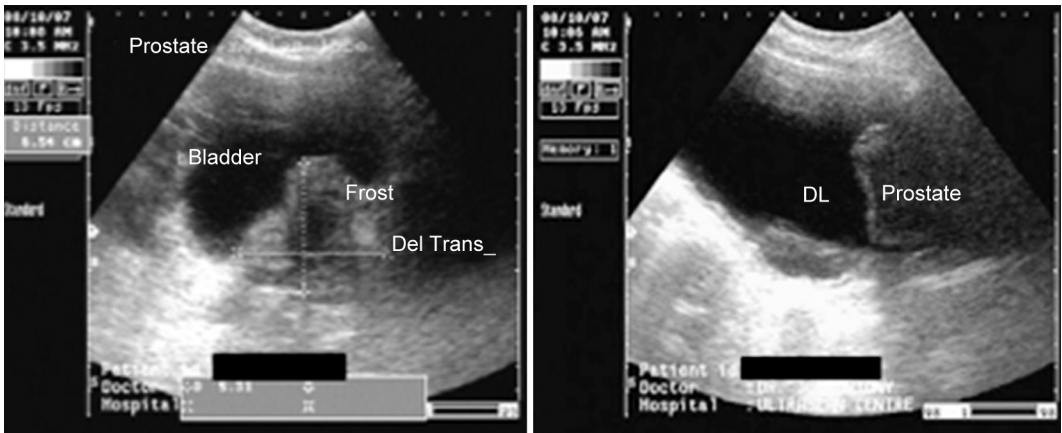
Transabdominal ultrasonography for prostate size
